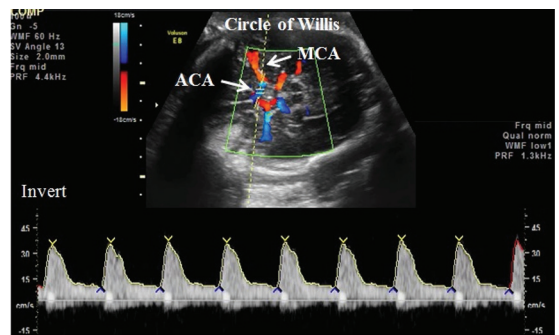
Location of the Doppler sample gate and acceptable Doppler waveforms of the anterior cerebral artery (ACA).
